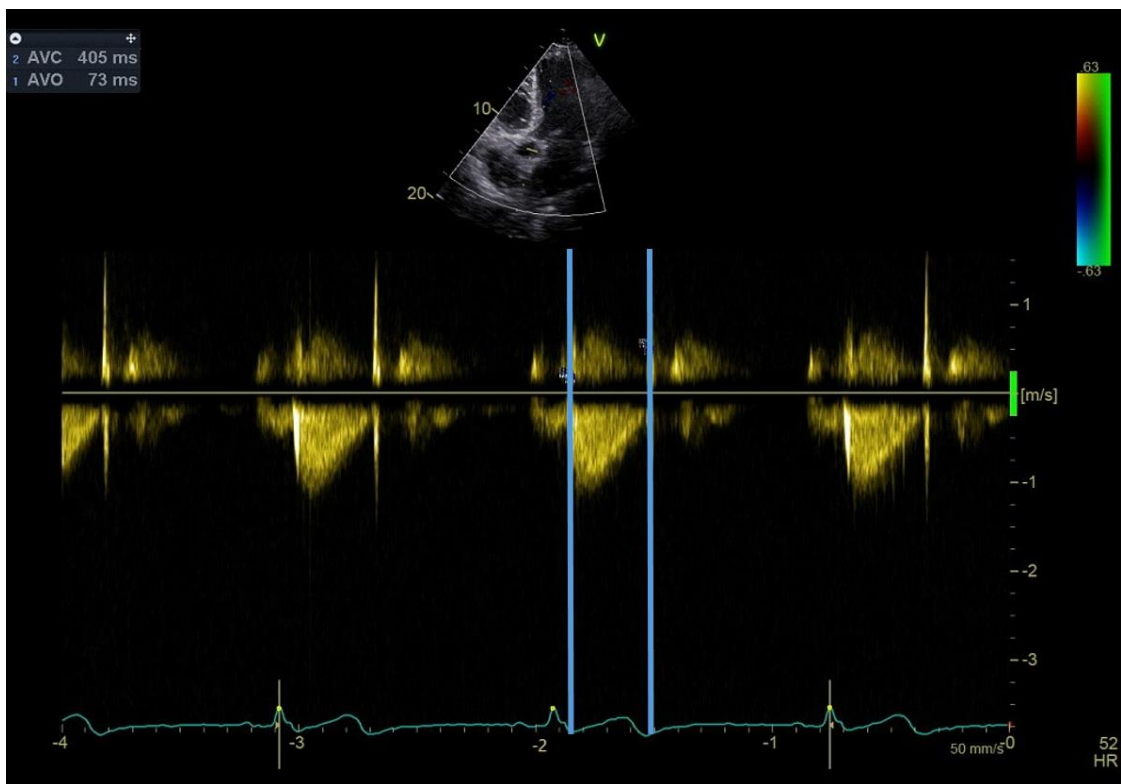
Second, aortic valve closure and opening times are measured using continuous-wave Doppler in apical 5-chamber.
